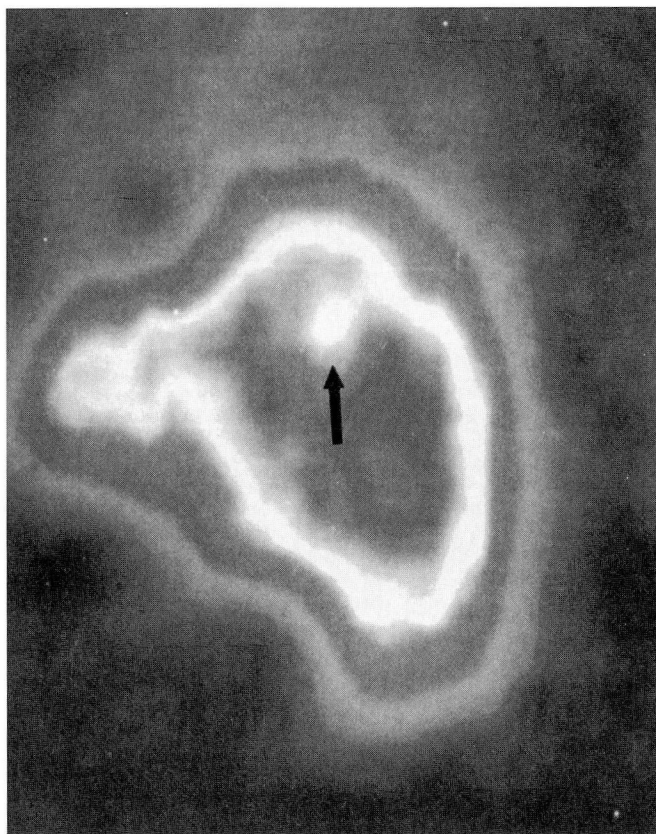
Sagittal section of the splenic SPECT scan (see text), showing the area of infarction in the posterolateral aspect of the spleen. The central lucency (arrow) represents hypoperfusion consistent with infarction.
